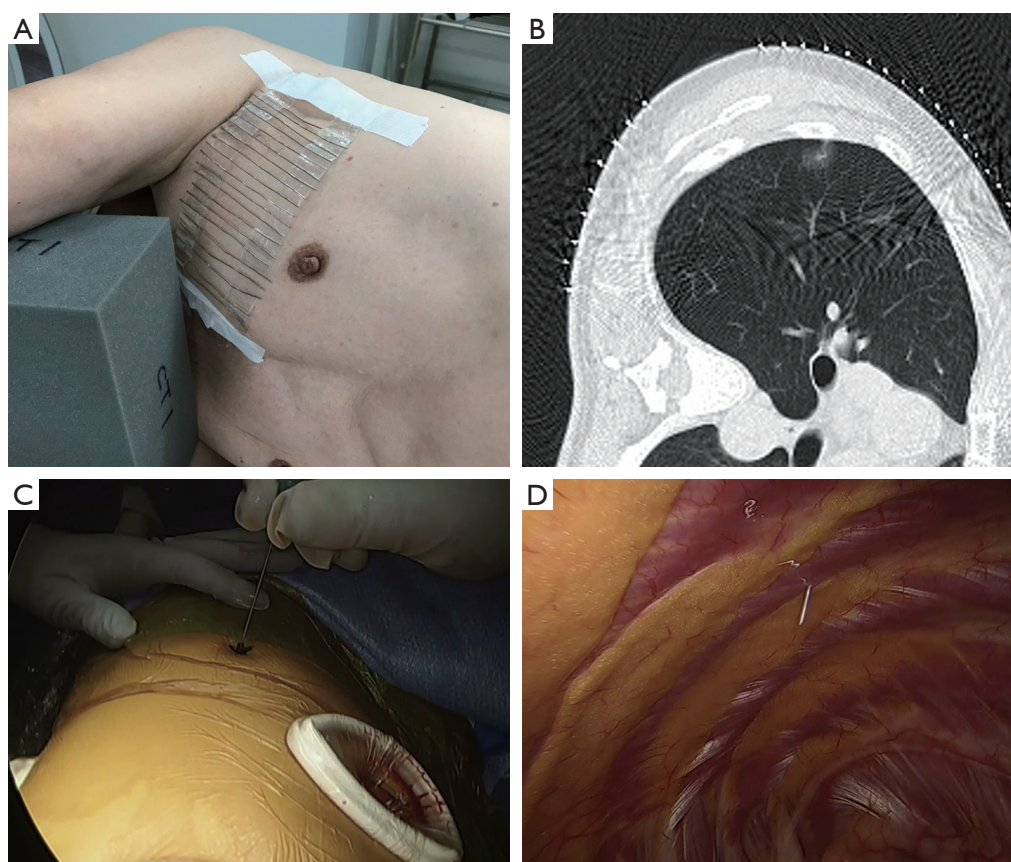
Our novel marking technique 1. (A) The guide markers on the body appear directly above the possible site of the lung tumor; (B) CT is performed 1 or 3 days before surgery. The arrow indicates the marking point above the tumor. The cross mark is marked on this point with a permanent marker; (C) the catheter needle is inserted into the pleural cavity from the marking site; (D) the needle tip indicates the pleural site above the tumor. CT, computed tomography.
